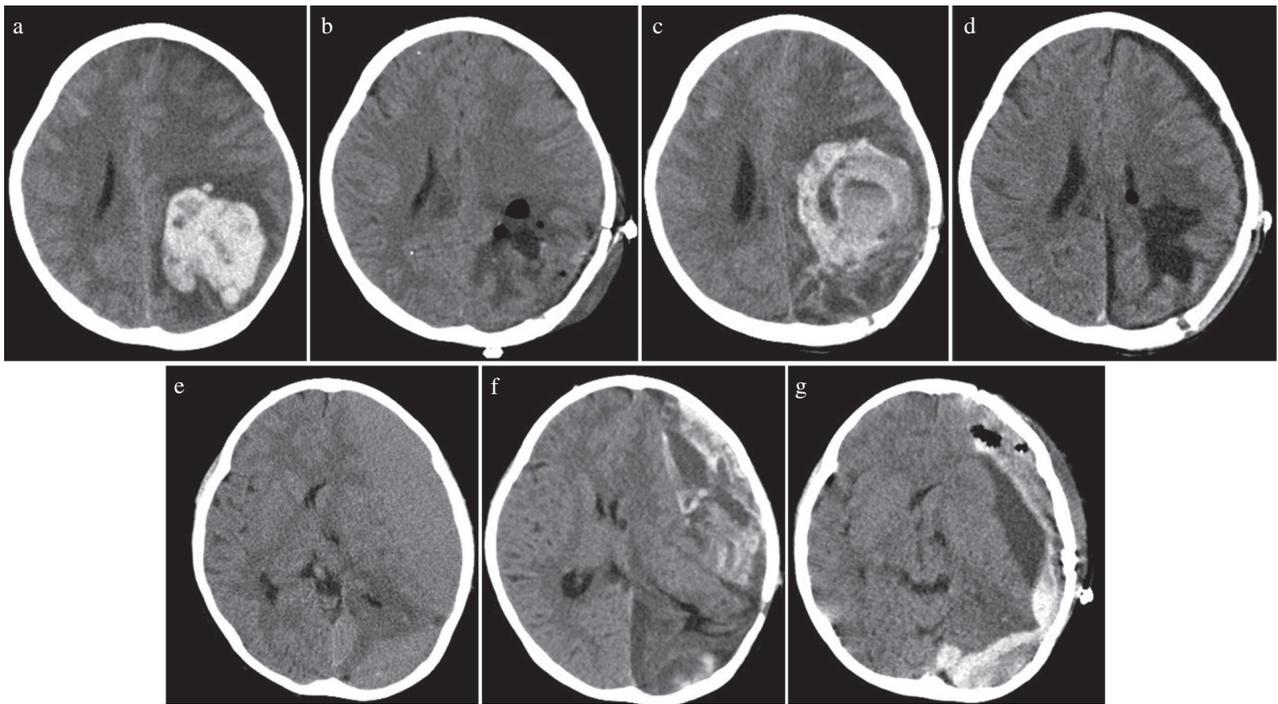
Head CT scans demonstrating the course of the intracranial hemorrhage. Head CT at presentation (a) demonstrates a left parietal subcortical hematoma that was evacuated by craniotomy (b). Head CT obtained on the 28th post-operative day after sudden deterioration in consciousness shows a recurrence of the left parietal subcortical hematoma (c) and the patient underwent another craniotomy. Post-craniotomy image shows collection of subdural fluid at the craniotomy site (d). Two months after the second craniotomy, the subdural effusion developed into a symptomatic chronic subdural hematoma (SDH) (e), which was evacuated by a burr hole surgery. Seven days later, the patient developed an acute SDH (f), for which he underwent a third craniotomy. Post-operative serial CT scans demonstrated progressive development of an acute/subacute SDH (not shown) resulting marked midline shift on the seventh day (g).
